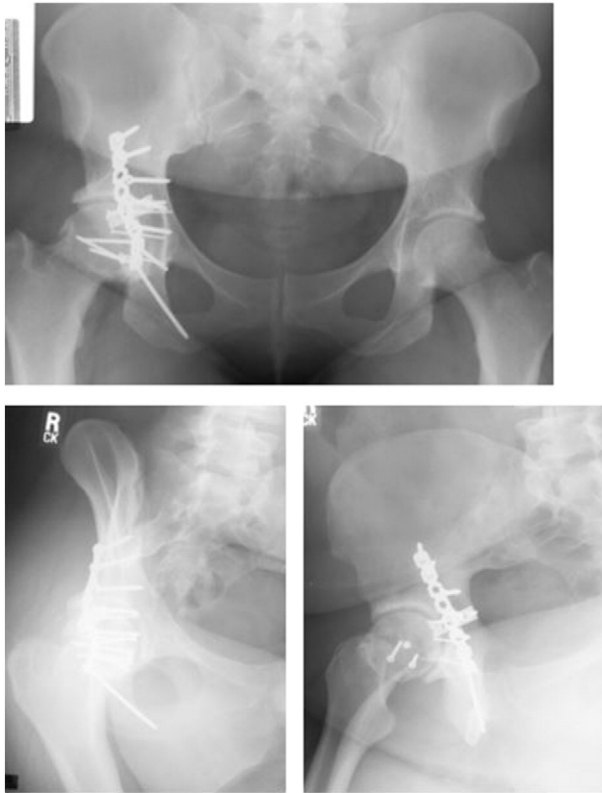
7 years f/u AP pelvis, obturator oblique and iliac oblique radiographs.
